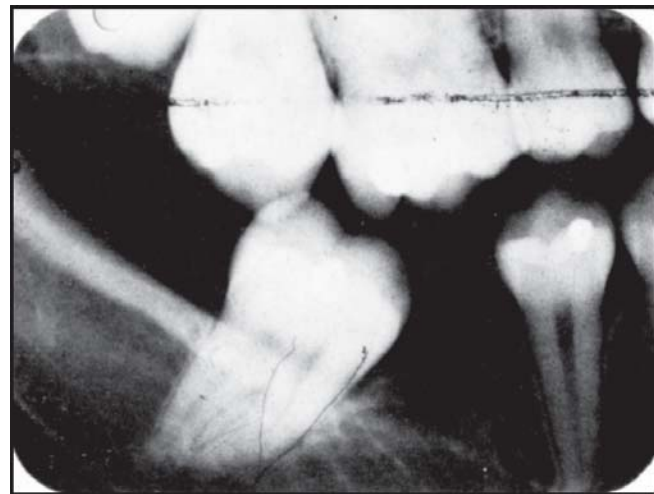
Dark spots or lines; due to the rubber rollers of the automatic machine, the rubber may actually come off the roller and adhere to the processed radiograph. Here static electricity can be seen superimposed over the mesial root of the mandibular molar
